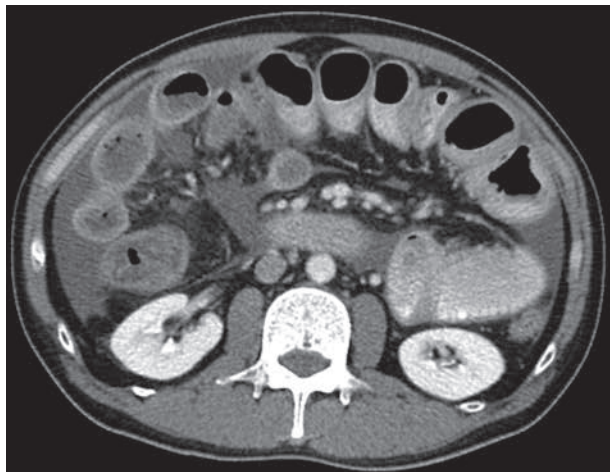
Diffused irregular wall thickening of small intestine and colon in abdominal computed tomography due to EGE.
